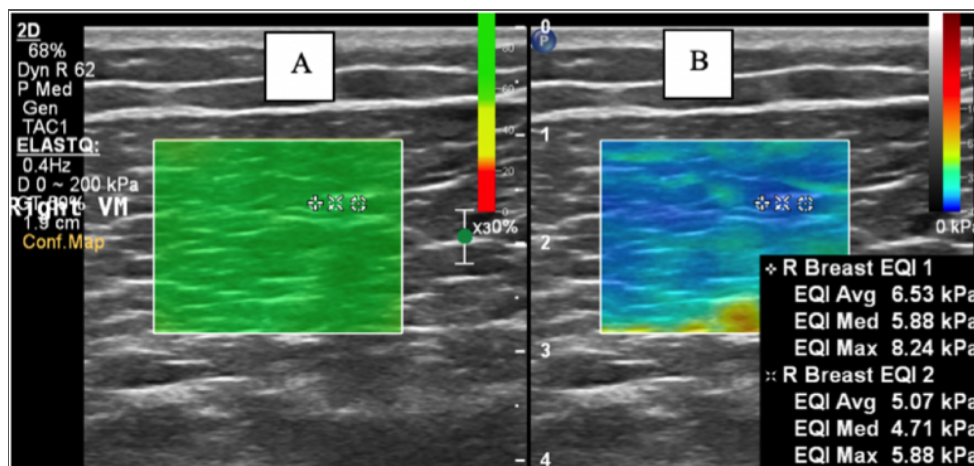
Measurement of elastic property of the Vastus Medialis (VM) in longitudinal view. (A) Longitudinal grey scale sonograms of VM on the identical scan planes. (B) Colour-coded box presentations of the VM elasticity (stiffer areas were coded in red and softer areas in blue) superimposed on a longitudinal grey scale sonogram of the VM
